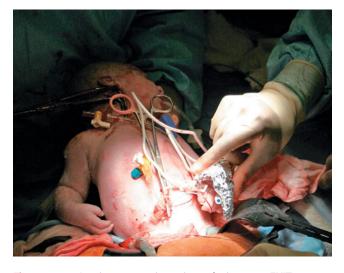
An intraoperative view during an EXIT procedure demonstrating continuous fetal monitoring using a sterile echocardiography, reflectance pulse oximetry, and IV access lines.
